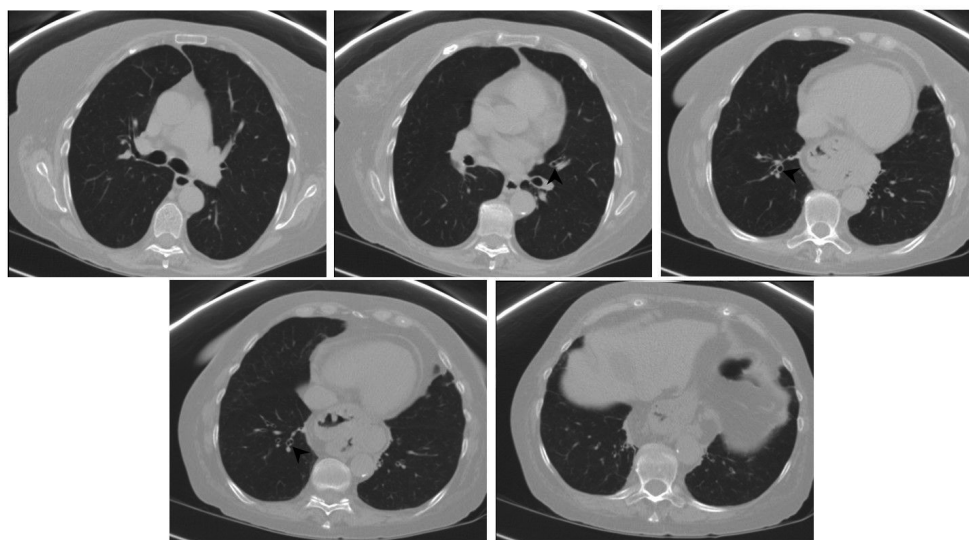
Chest computed tomography at the end of treatment for *Aspergillus* spp, showing radiological resolution of the pulmonary parenchymal infiltrates but persistent features of airways disease and bronchial wall thickening (arrowhead).
